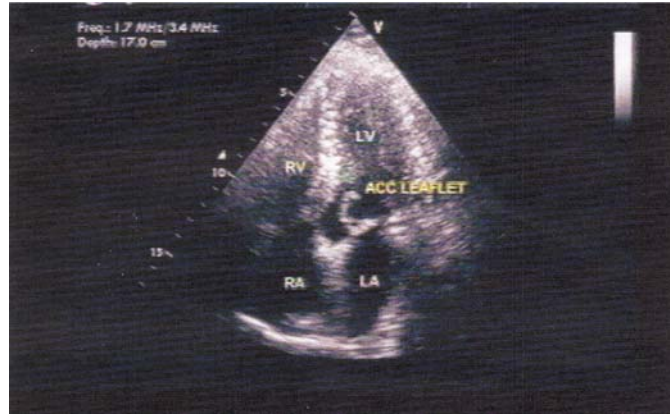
Transthoracic Echocardiography showing accessory mitral leaflet tissue attached to AML
